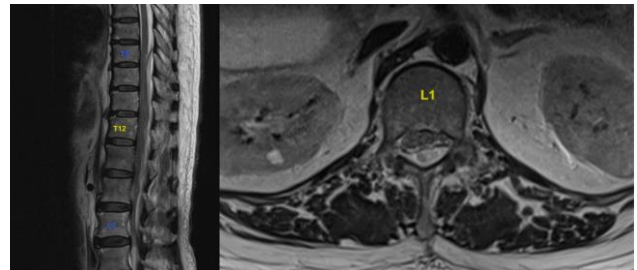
MRI ThoracoLumbar(T2)
